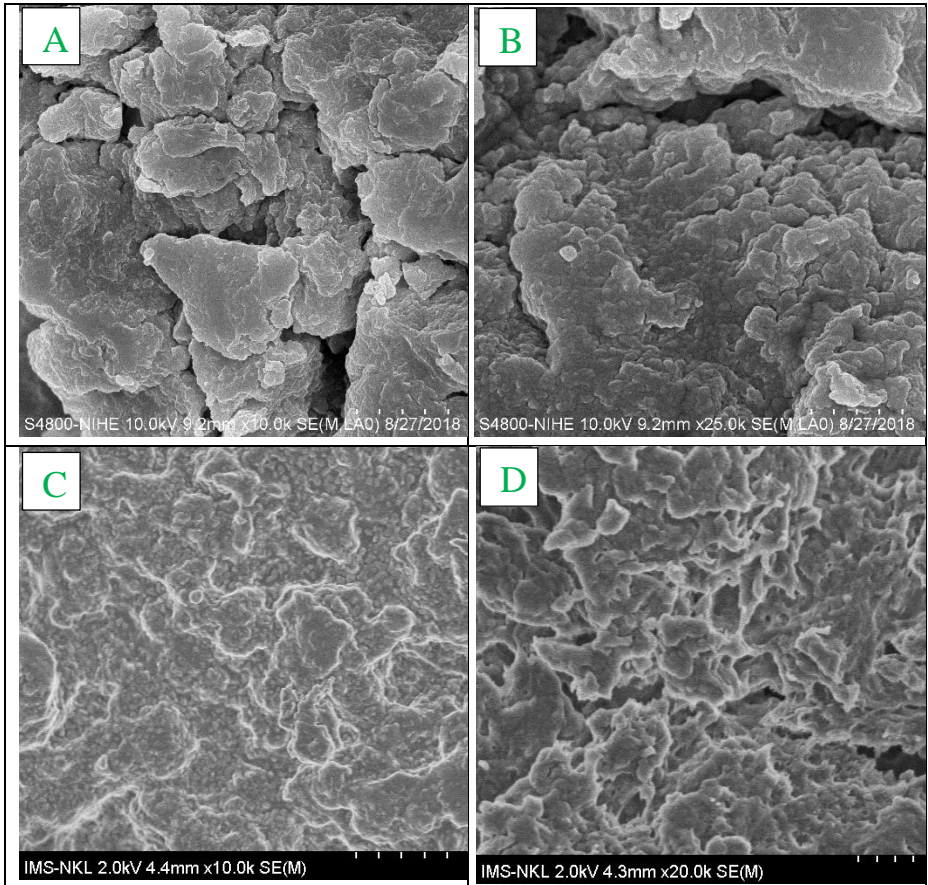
FESEM photos of CT (A, B) and CC (C, D)
